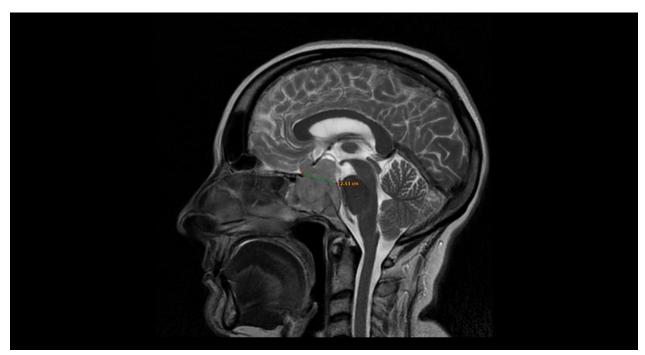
MRI four months after with no significant further tumor size reduction
